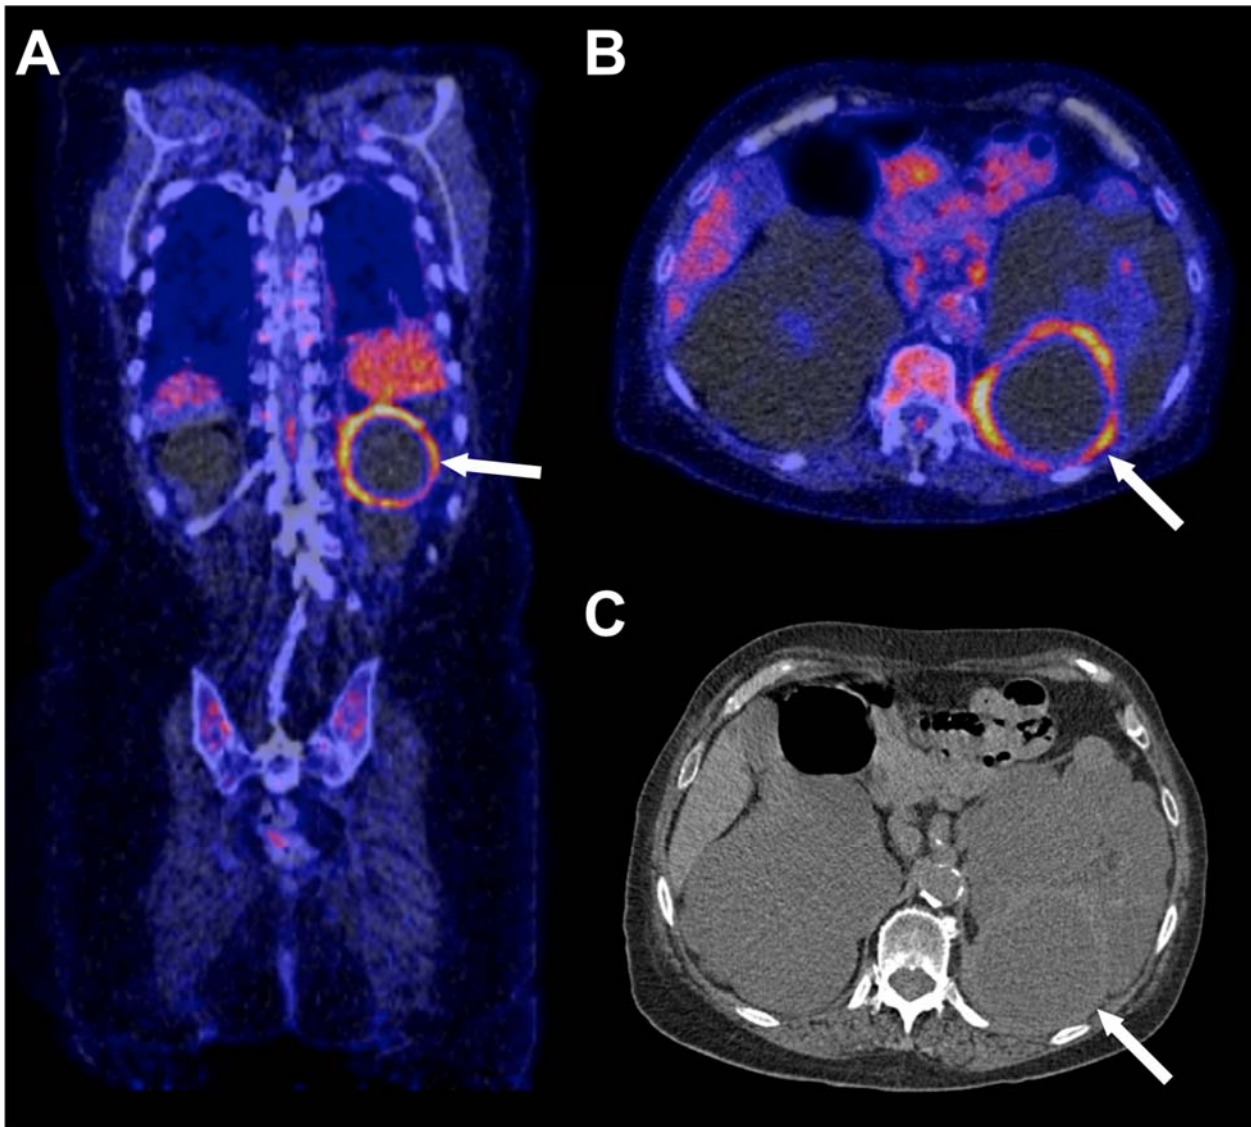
A 79-year-old woman with ADPKD in whom FDG-PET/CT was positive for renal cyst infection. Coronal (A) and axial (B) fused FDG-PET/CT shown an FDG-avid cyst wall in the left kidney (arrows), indicative of infection. Axial CT at the same level show the cyst (arrow) with slightly thickened and hyperattenuating wall. The criteria for cyst infection according to Sallée et al. (5,10-13) were also met in this patient.
